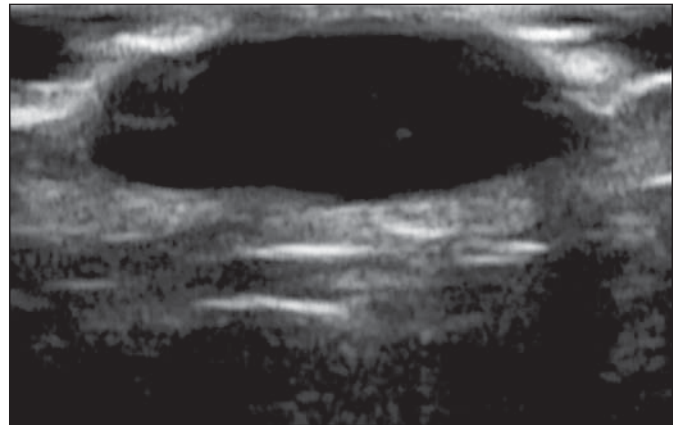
71-year-old man with cutaneous melanoma. Two-dimensional ultrasound image shows nonhomogeneous hypoechoic lesion localized to lumbar region.
